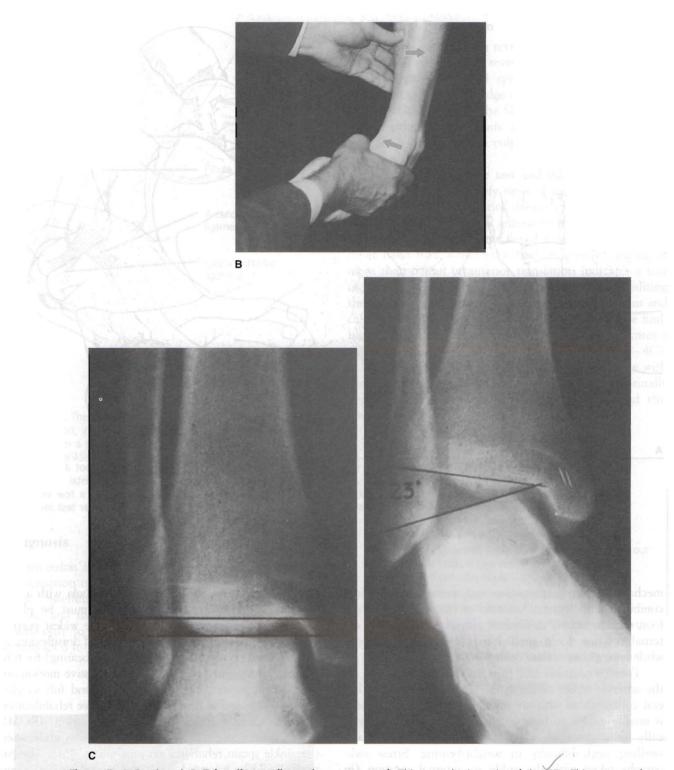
Continued. B,* Talar tilt test (inversion stress test). This tests the integrity of the CFL. This test may be performed with a commercial jig or leaded hands under radiographs. Invert the foot while stabilizing the tibia with one hand and the subtalar joint with the other. C, Left, AP view of the ankle prestress. *Right,* AP view of the ankle with inversion stress reveals marked lateral ligament injury. (*A, Left,* From Ganley TJ, Flynn JM, Pill SG, Hanlon PA: Ankle injury in the young athlete: fracture or sprain? J Musculoskel Med 17:311–325, 2000. Artist: Teri J. McDermott; *Right,* from Baker CL, Todd JL: Intervening in acute ankle sprain and chronic instability. J Musculoskel Med 12[7]:51–68, 1995; *B,* from Meisterling RC: Recurrent lateral ankle sprains. Physician Sports Med 21[3]:123–135, 1993; *C,* from Lassiter TE, Malone TR, Garrett WE: Injuries to the lateral ligaments of the ankle. Orthop Clin North Am 20:632, 1989.)
